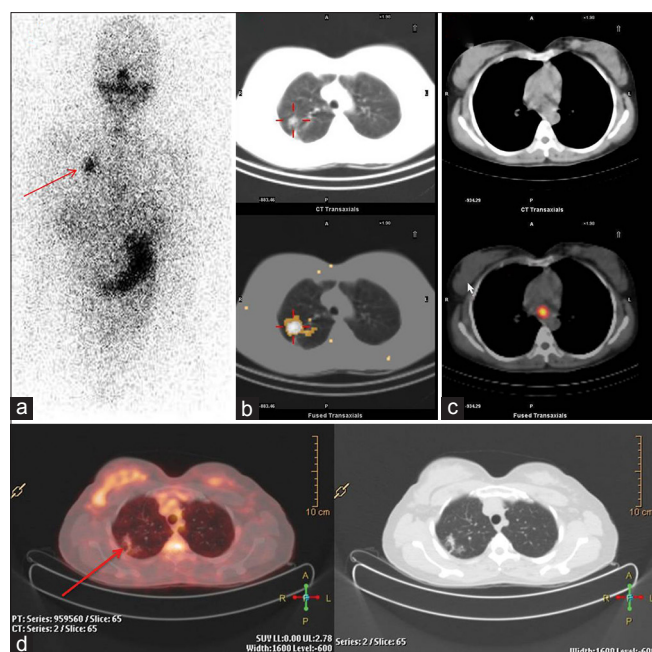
Planar ^{131}I whole body scan (a) showing iodine-avid focus in the right upper lung. Correlative SPECT-CT (b and c) in the lung and mediastinal window and FDG-PET/CT images (d) showing a spiculated nonenhancing lesion with adjacent area of fibrosis in the posterior segment of the right upper lobe and 1 cm-sized round node in the subcarinal region. CT features of the lung lesion on the right were in favor of benign pathology (nonactive infective sequela)
